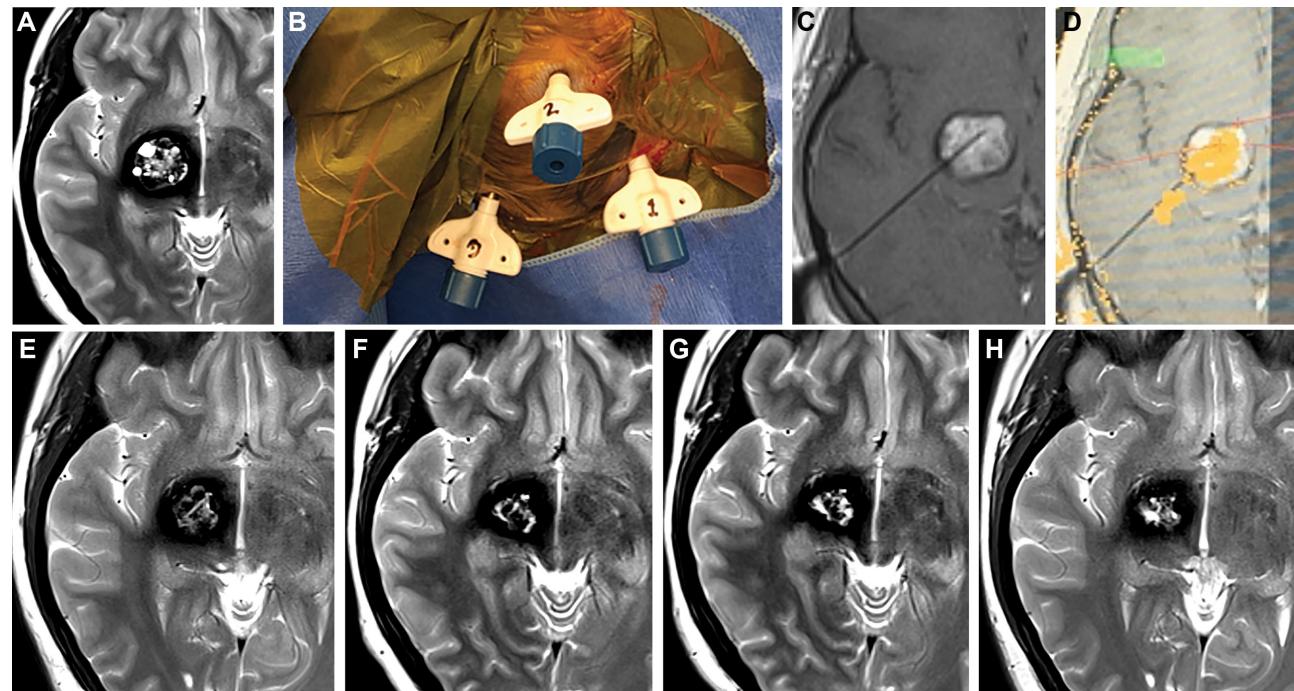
Ablation of CCM of right midbrain/thalamus in patient 3. A, Preoperative axial T2-weighted image shows the mixed-intensity lesion prior to ablation. B, Intraoperative photograph of Visualase (Medtronic Inc) stereotactic bolts (placed by CRW headframe) placed for 3 planned trajectories. C, Intraoperative para-axial T1-weighted image showing cannula placement within lesion. D, Intraoperative screenshot from Visualase workstation showing para-axial T1-weighted monitoring plane with processed thermal damage estimates (orange pixels) derived from gradient echo-weighted MR thermography. Follow-up axial T2-weighted image at E 6 mo and F 1 yr showing partial involution that then remained stable at G 2 yr and H 3 yr.
